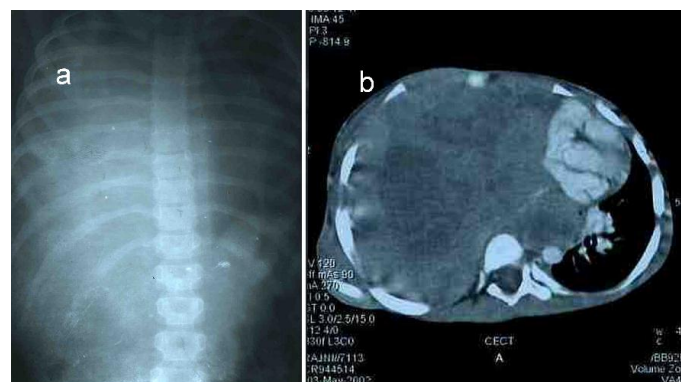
Chest X-ray revealing homogenous opacity on right side; b. CECT showing subcutaneous nodule along with right sided opacity.
